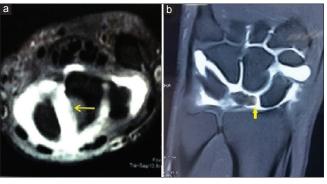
Scapholunate ligament tear on magnetic resonance arthrography, (a) complete scapholunate tear (yellow arrow) with contrast leak – axial T1-weighted fat saturation magnetic resonance arthrography, (b) complete scapholunate tear and diastasis (yellow arrow) with contrast leak into the midcarpal space – coronal T1-weighted fat saturation magnetic resonance arthrography
